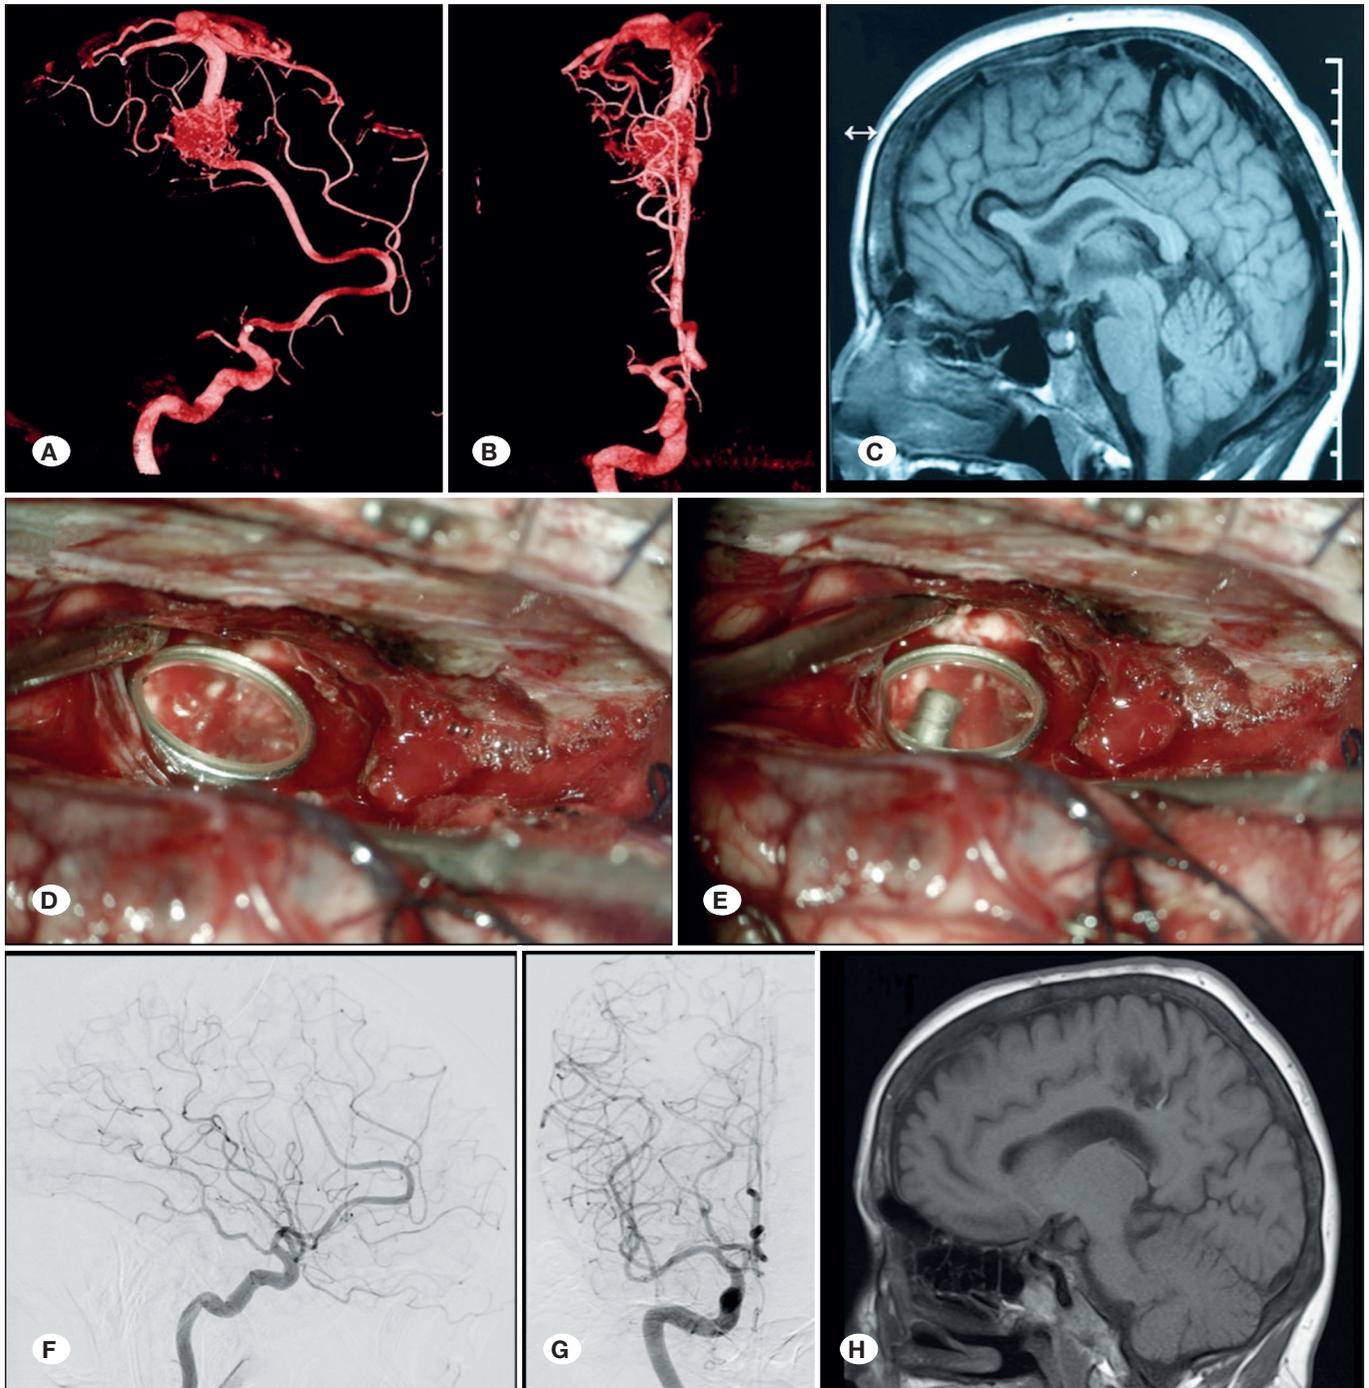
Lateral (A) and anteroposterior (B) 3D angiography showing an interhemispheric AVM with an arterial feeder from the right anterior cerebral artery and a single draining vein in the superior sagittal sinus. (C) Preoperative sagittal T1-weighted MRI showing the AVM in the paracentral sulcus and the related flow void. (D, E) Intraoperative pictures obtained during a right interhemispheric contralateral transfalciine approach revealing the helpfulness of the micromirrors in detect the superior pole of the AVM hidden above the paracentral lobe. Postoperative digital subtraction angiography in lateral (F) and anteroposterior projection (G) documenting the complete resection of the AVM. (H) Sagittal T1-weighted postoperative MRI.
